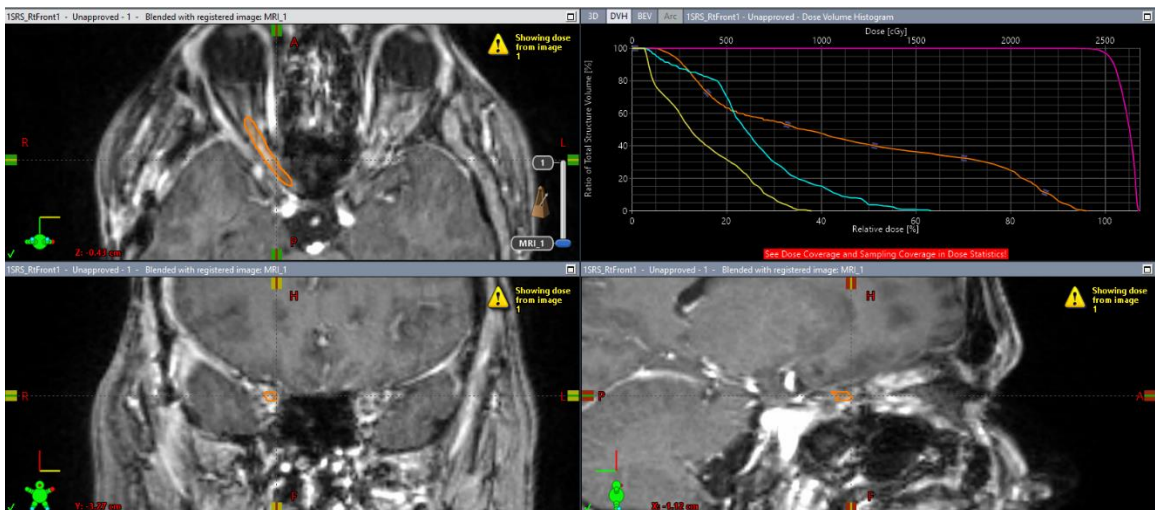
Right Optic Nerve, MRI
